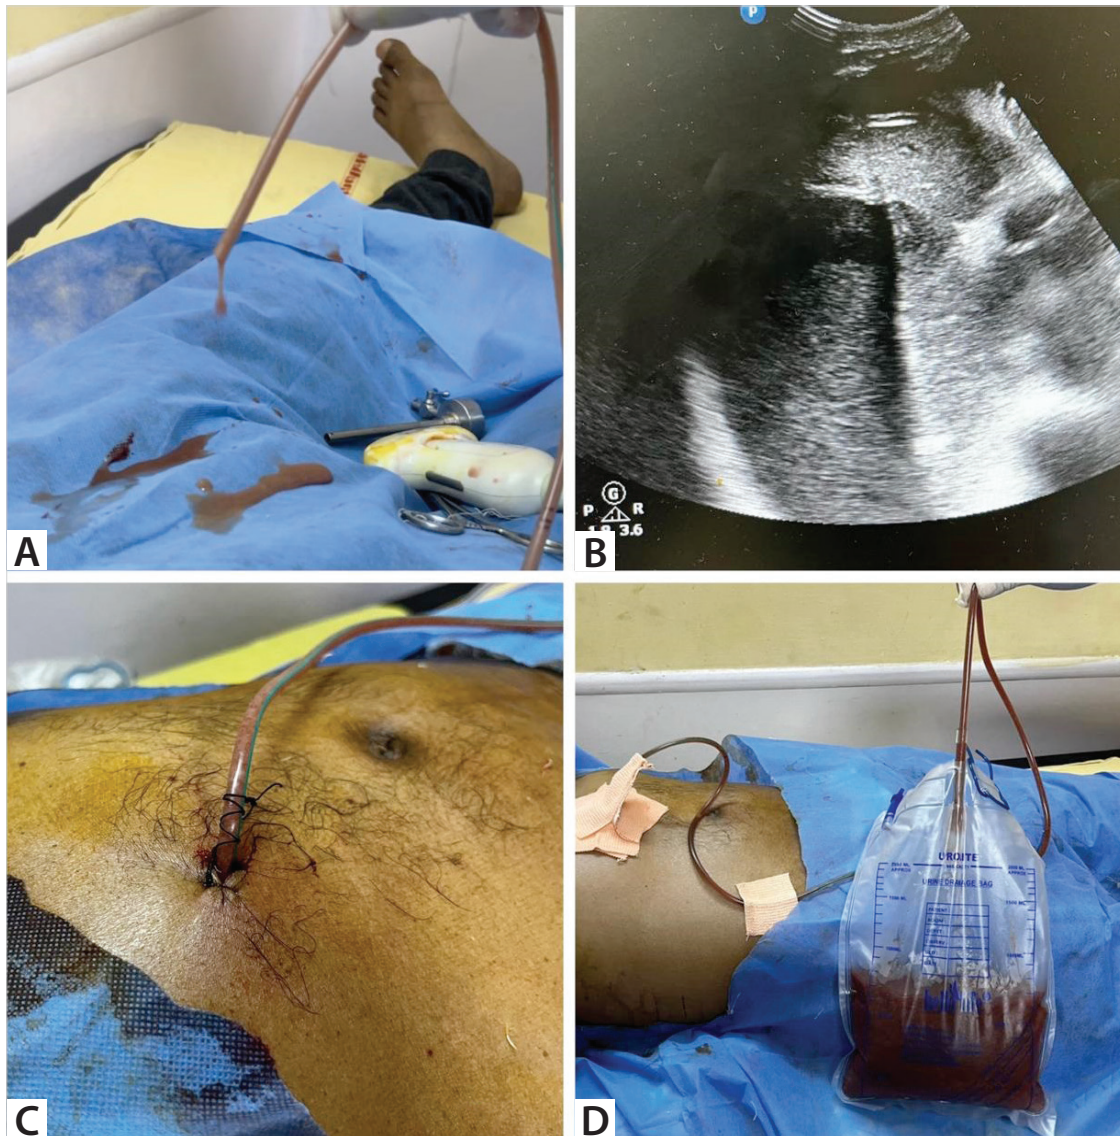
Confirmation and fixation of RT. A. Flow of pus through the Ryle's tube confirmed. B. Ryle's tube placement is also confirmed through ultrasound imaging. C. Fixation of Ryle's tube with skin. D. Pus drained via Ryle's tube after fixation.
